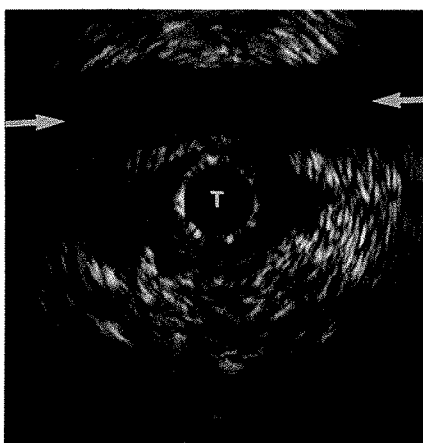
Patient with distal ureteral stone. Cross-sectional sonogram of distal left ureter shows thickened hypoechoic mucosa (arrows). Located within area of thickened mucosa was a calculus measuring 4.5 mm (cursors) with distal acoustic shadowing. Reflection from guidewire (arrowhead). T = transducer.
